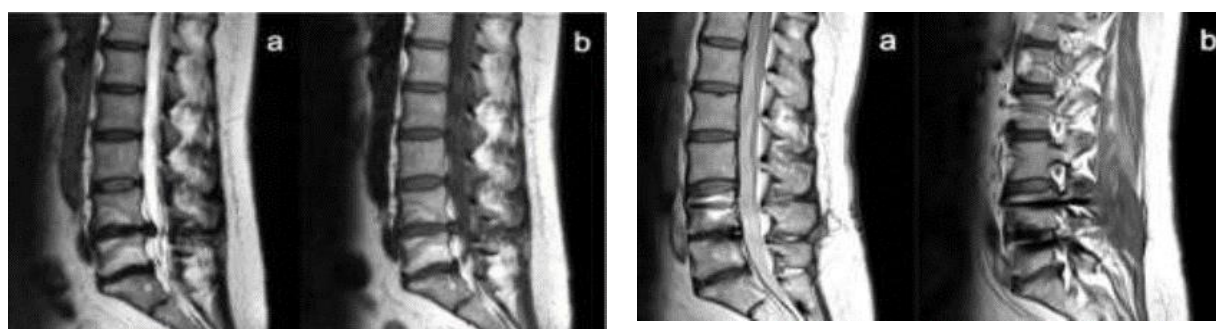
Preoperative (Left) and postoperative (Right) MRI showing the excision of the recurrent disc and the implants.
